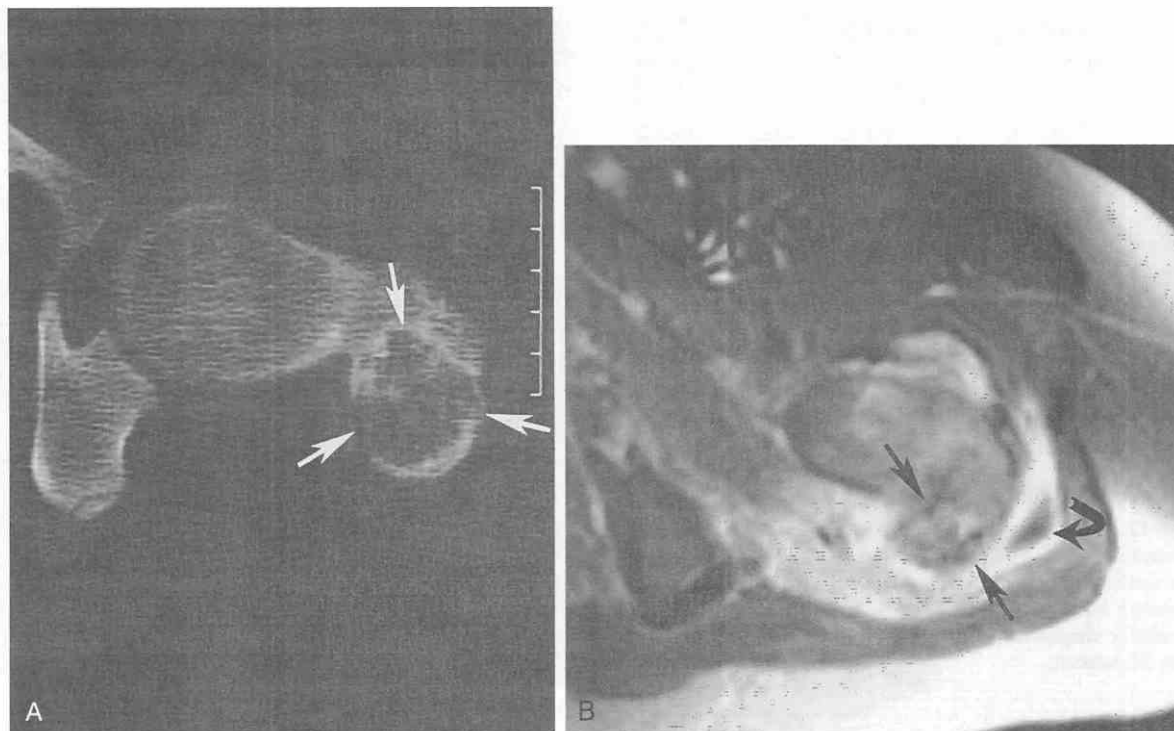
Chondroblastoma of the greater trochanter of the femur in a 14-year-old boy. *A*, CT shows a relatively well defined lucent expansile lesion with a few punctate internal calcifications (*arrows*). *B*, Axial postgadolinium T1-weighted image (TR = 550 msec, TE = 18 msec) with fat saturation shows marked enhancement within the adjacent soft tissues as a result of irritation. The lesion (*arrows*) enhances minimally. A small bursa is evident (*curved arrow*).
